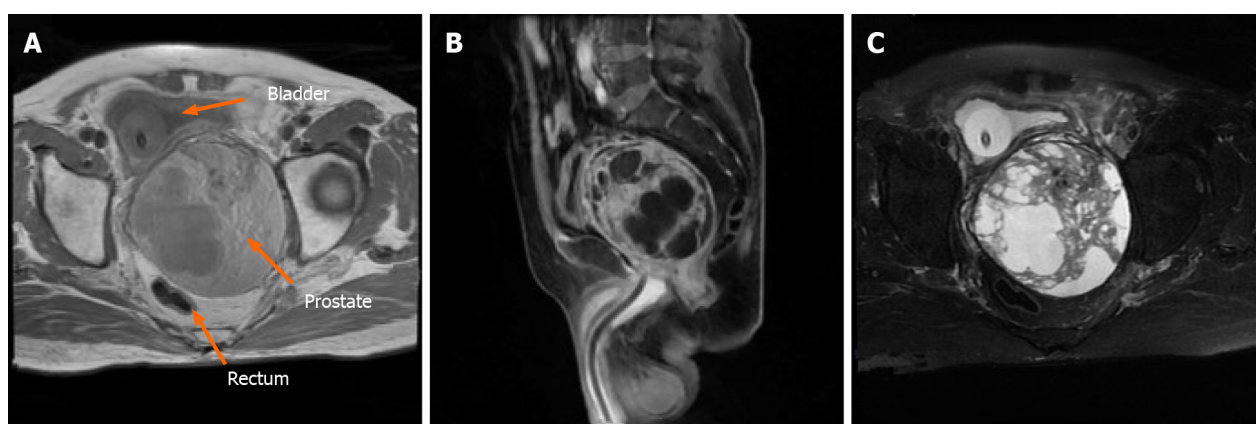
Magnetic resonance imaging revealed that the prostate was evidently enlarged with resultant compression and right-sided deviation of the urinary bladder and rectum (as indicated by arrowheads). Irregular density shadows could be seen in the prostate gland. T2 weighted imaging showed nonhomogeneous and height signals internally. The peripheral zone of the prostate was unclear with bilateral seminal vesicles atrophied and no evidence of lymph node involvement in the pelvic cavity or tumor invasion to the surrounding structures.
